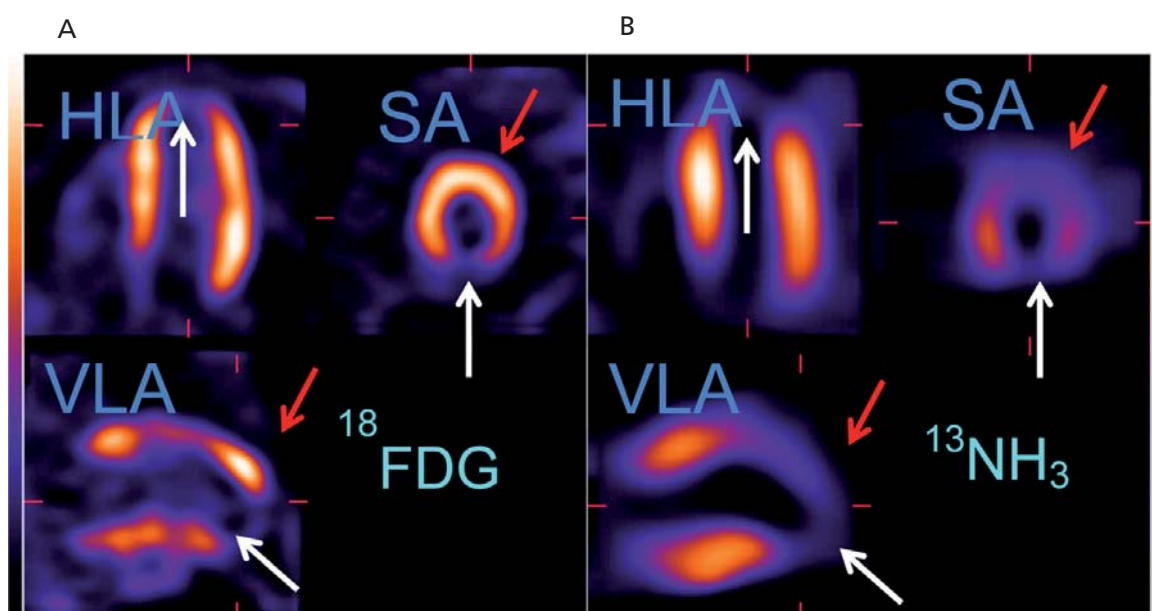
PET with NH_3 and ^{18}F -FDG to assess myocardial viability. Panel (A) myocardial metabolism, panel (B) – myocardial perfusion. Regional myocardial ^{18}F -FDG uptake (A) is disproportionately enhanced compared with regional myocardial blood flow assessed by $^{13}\text{NH}_3$ (B), metabolism – perfusion mismatch and is indicative of hibernating myocardium (red arrows). The lack of ^{18}F -FDG uptake compared with lack of regional myocardial blood flow is indicative of scar (white arrows). HLA – horizontal long axis; SA – short axis; VLA – vertical long axis. (Reproduced with permission of G. Romanowicz, MD, PhD, Department of Nuclear Medicine, Medical University of Gdansk, Poland)
